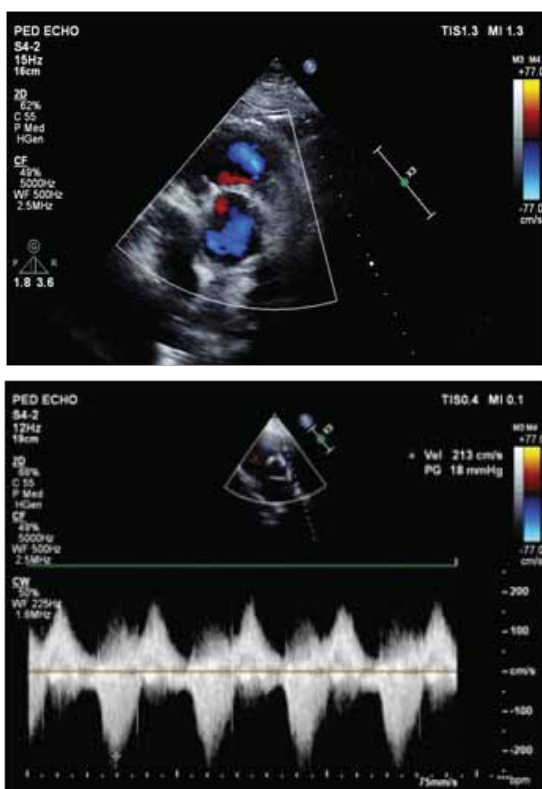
depicts echocardiogram finding of reconstructed PV with minimum gradients across the neo valve.
